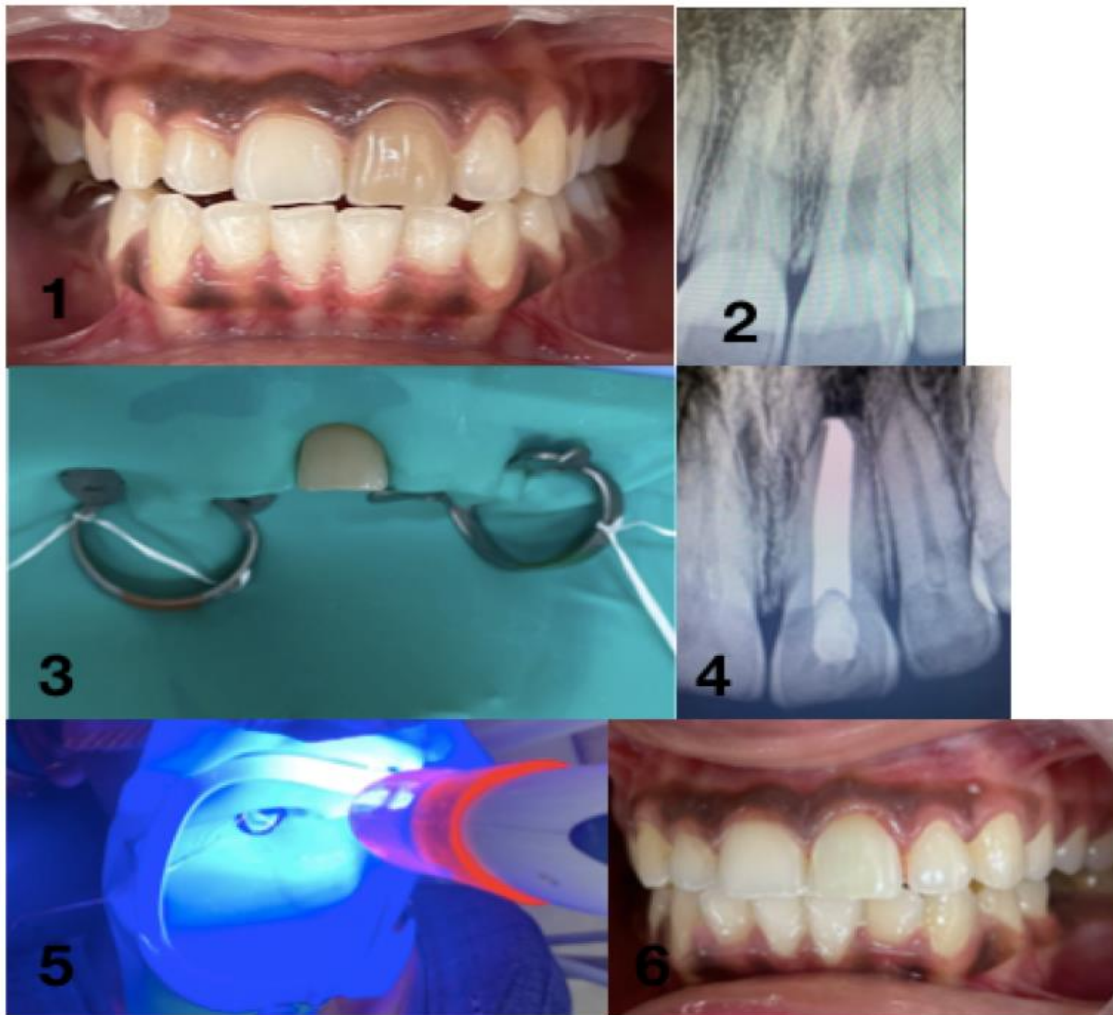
pre operative image, Figure 2: pre operative radiograph, Figure 3: rubber dam isolation, Figure 4: Obturation and GIC barrier, Figure 5: light activation, Figure 6: post operative intra oral image.
